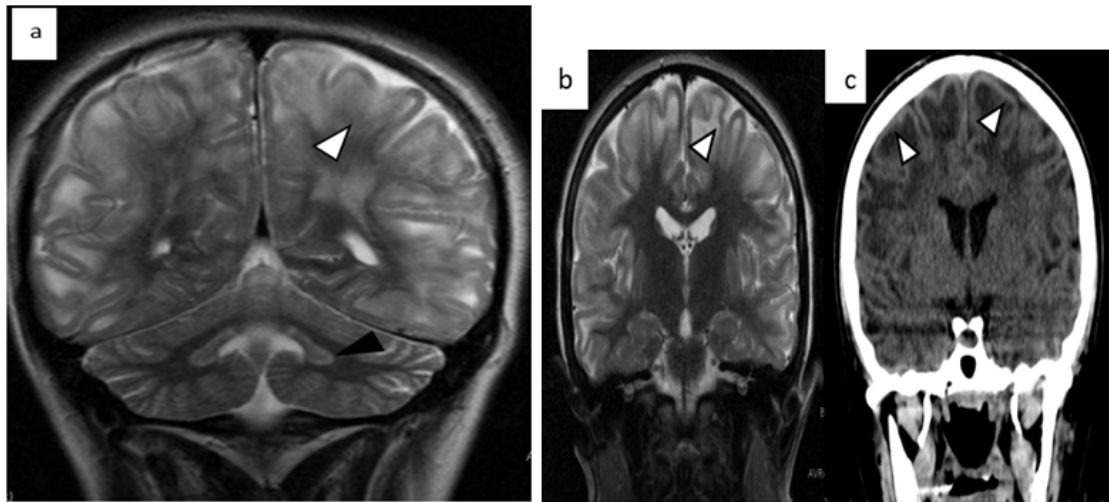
13 years old girl's brain Coronal T2 MR and CT image: a) Coronal T2 MR of the brain shows in the posterior fossa, a high signal due to involvement of the bilateral dentate nucleus (black arrowhead), bilateral and symmetrical high signal in the subcortical U-fibers of temporal and parietal lobes (white arrowhead). b) Coronal T2 MR - preserved the periventricular region's deep matter and brainstem. Bilateral and symmetrical high signal in the subcortical U-fibers of temporal and parietal lobes (white arrowhead). c) Coronal CT of the same brain shows hyperdense bilateral and symmetrical subcortical white matter lesions of temporal and parietal lobes (white arrowhead)
